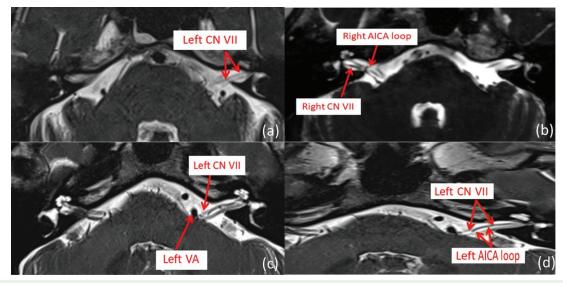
The MRI and MRA brain findings demonstrated radiologic nerve compression of the cranial nerve VII (CN VII); (a) no neurovascular compression (NVC), (b) CN VII abutment from the anterior inferior cerebellar artery (AICA) loop, (c) CN VII indentation from the left vertebral artery (VA), (d) CN VII deviation from the left AICA (arrow).
